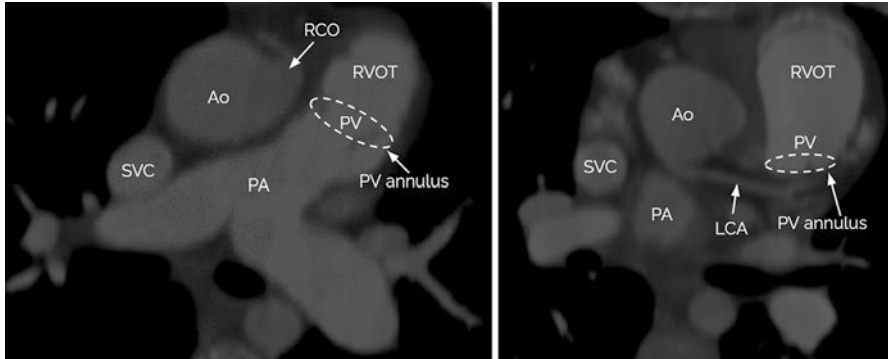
Inferior views of axial plane slices from patient CT scan. LEFT: location of RCO relative to PV annulus. RIGHT: location of LCA relative to PV annulus. Nomenclature from left to right: SVC, superior vena cava; Ao, aorta; PA, pulmonary artery; RCO, right coronary ostium; PV, pulmonary valve; RVOT, right ventricular outflow tract; LCA, left coronary artery
